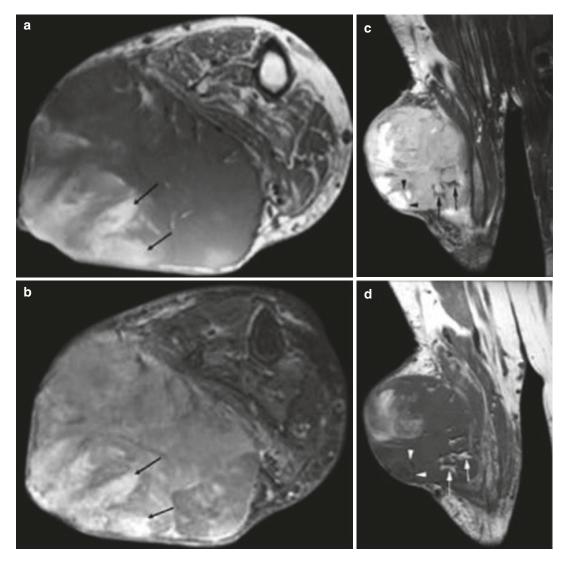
77-year-old woman with ossifying fibromyxoid tumor of the calf. (a) Axial T1-weighted MR image. (b)Axial T2-weighted MR image with fat saturation (FS). (c) Coronal T2-weighted MR image. (d) Coronal T1-weighted MR image. Axial T1W (a) and T2W FS (b) images through the right calf demonstrate the mass, which is subcutaneous and seen to displace, rather than infiltrate, the adjacent musculature. The mass is predominantly isointense to muscle on T1W image and of intermediate-to-high signal intensity on T2W FS image. Foci of hyperintensity
